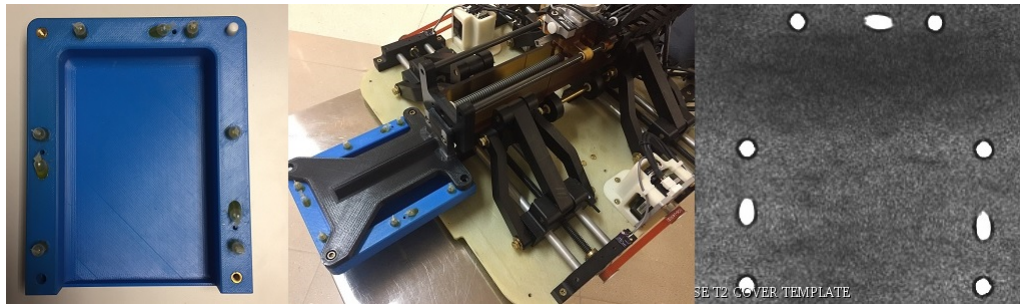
The Z-Frame used for robot-scanner registration. Left) The 3D printed Z-Frame which holds nine MR visible fiducials in perpendicular “Z” configurations, Center) the Z-Framer attached to the robot, Right) an MR image slice showing the fiducial markers used to register the robot location to scanner coordinates.
